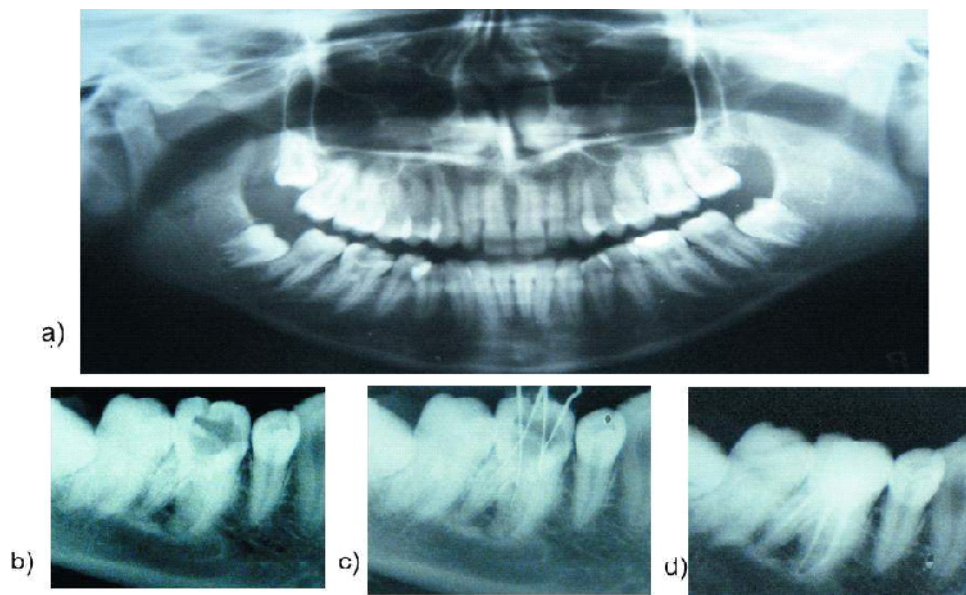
(a) : Panoramic radiograph showing mandibular left first molar tooth with an extensive caries.(b) Preoperative radiograph showing an additional distal root (c) working length radiograph. (d) Radiographic control following obturation of the four root canals.
